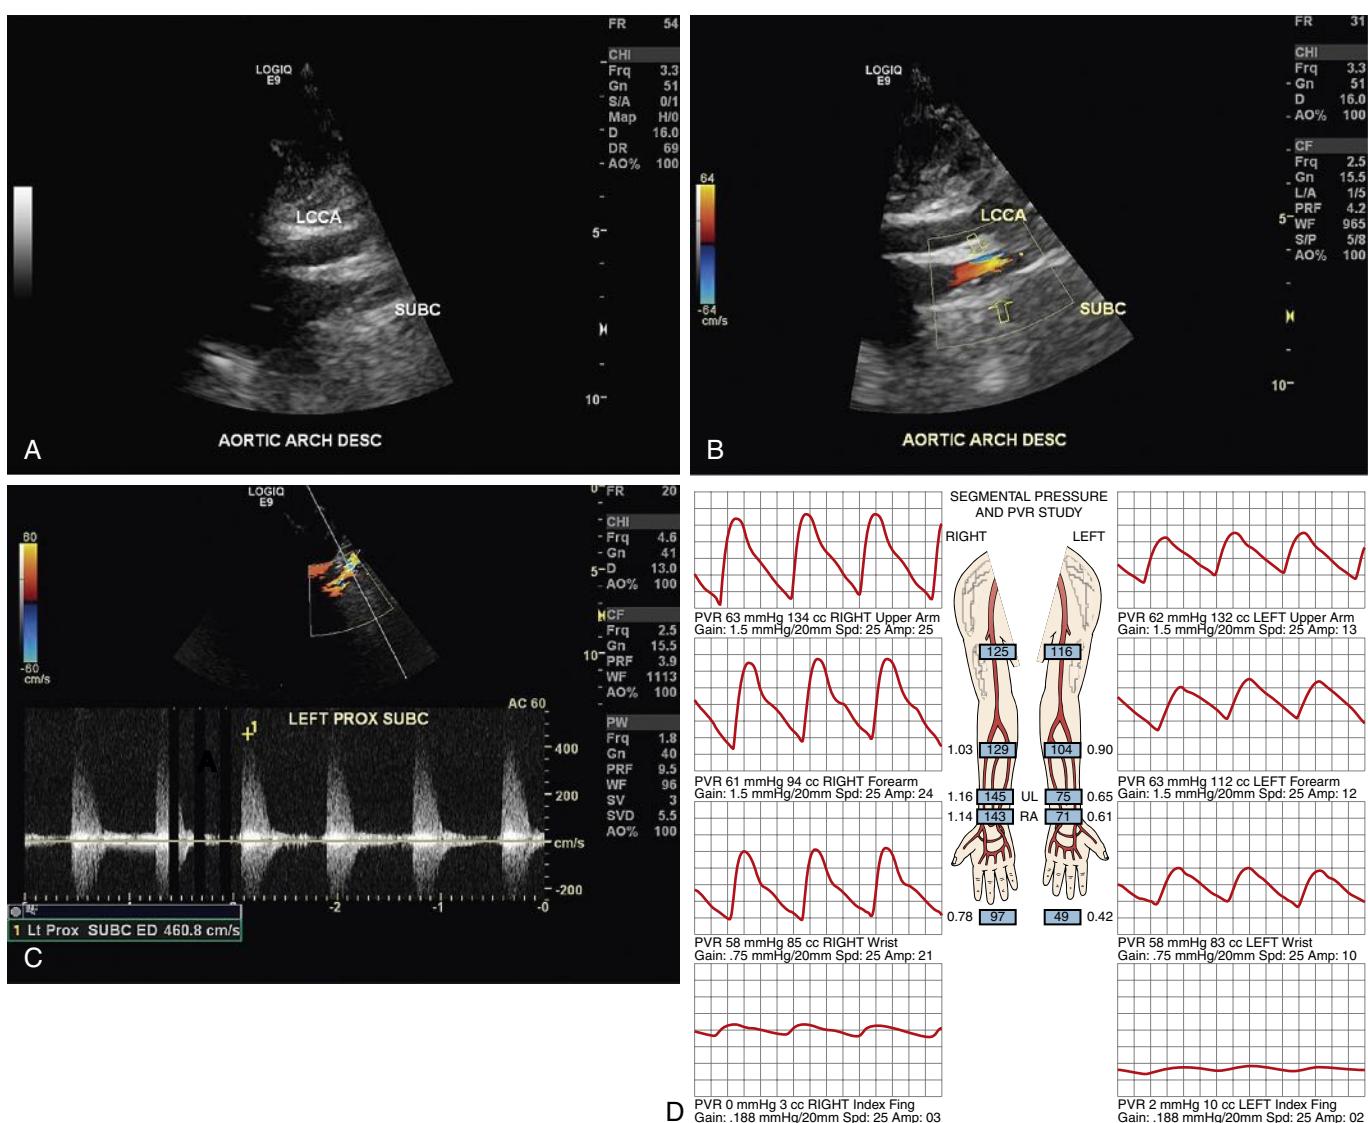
Left Subclavian Artery Stenosis Demonstrated on Ultrasound. (A) B-mode ultrasound image of the descending aortic arch with the left common carotid artery and left subclavian artery origins clearly visible. A bulky atherosclerotic plaque is narrowing the origin of the left subclavian artery. (B) Color Doppler image demonstrating arterial flow through the stenosis at the origin of the left subclavian artery (yellow arrows). (C) Color duplex image with the velocity through the left subclavian artery stenosis dramatically elevated at 460.8 cm/s. (D) Segmental pressures and pulse volume recordings of the same patient identifying reduction in PVR amplitude and latency and reduced wrist and finger to brachial index.
